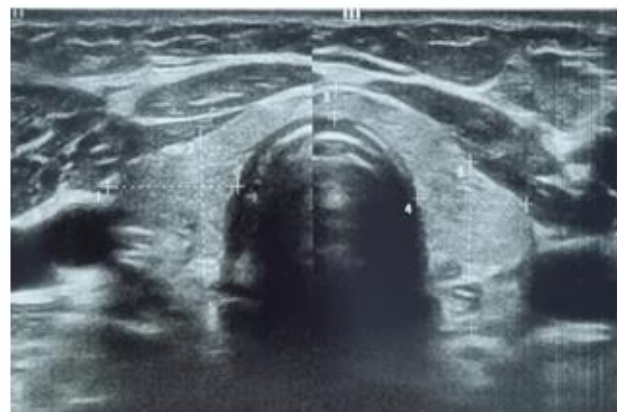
Thyroid ultrasound after 3 months since initial diagnosis of the thyrotoxicosis: stationary
